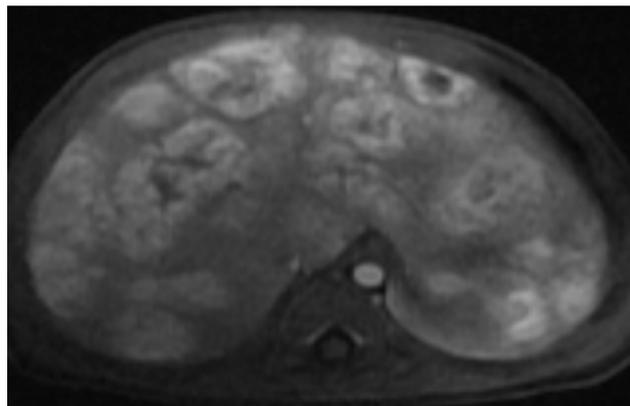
MRI images at presentation: numerous rounded lesions all over the hepatic segments with characteristic and high signal intensity (hyperintense) at T2-weighted image.
